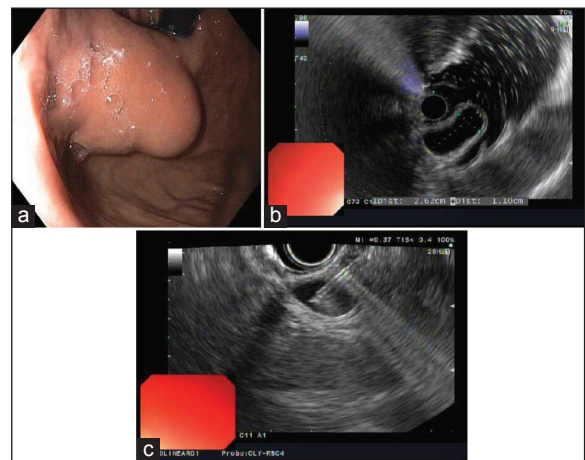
Gastric duplication cyst. (a) Endoscopic view; (b) Endoscopic ultrasound (EUS) view; (c) EUS-guided fine-needle aspiration of the same lesion
